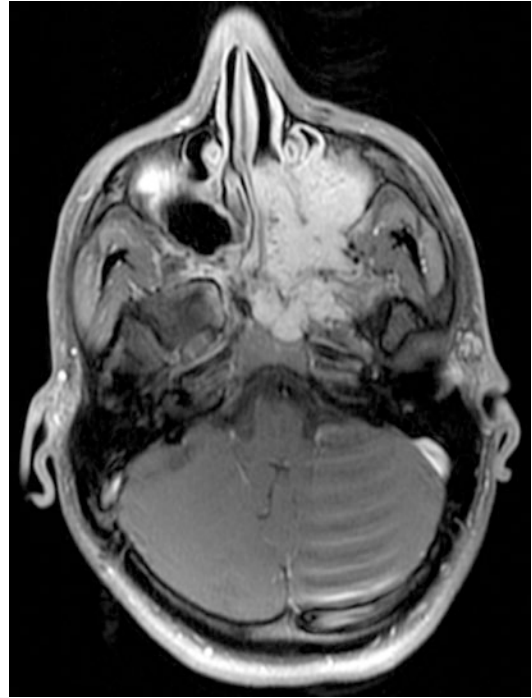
Pre-operative axial contrast-enhanced T1 MRI scan demonstrating tumor extent
